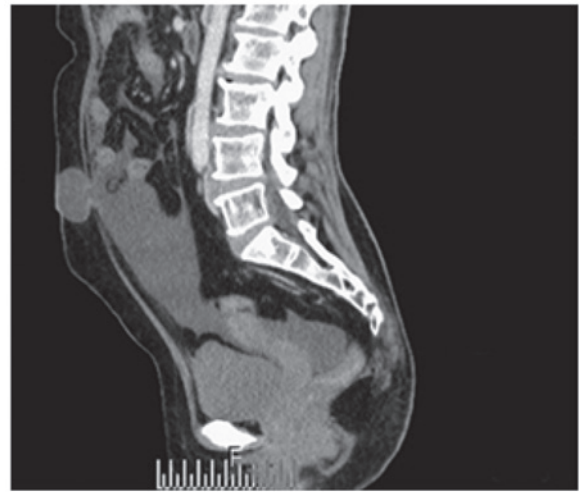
Presence of an umbilical hernia with abdominopelvic effusion was observed using computed tomography.
